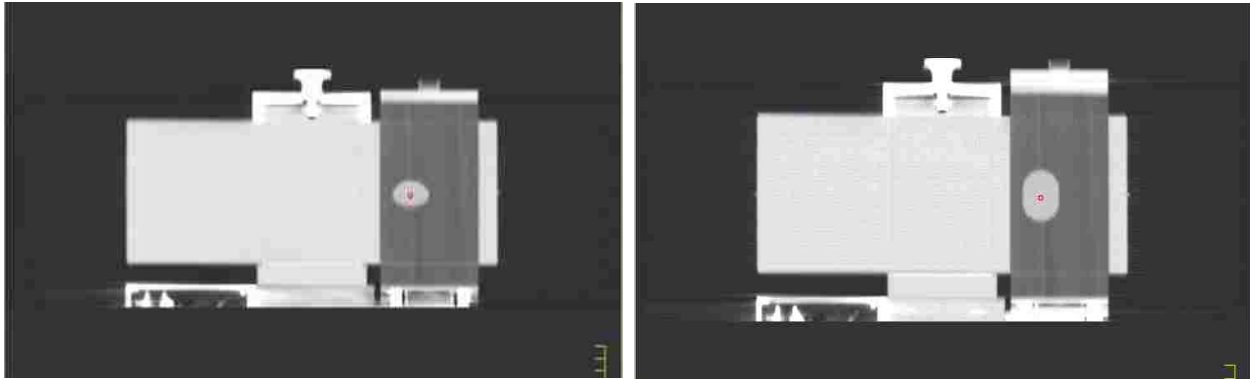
Coronal slice of free breathing-CT data set and MIP CT data set in Pinnacle³ treatment planning system.
